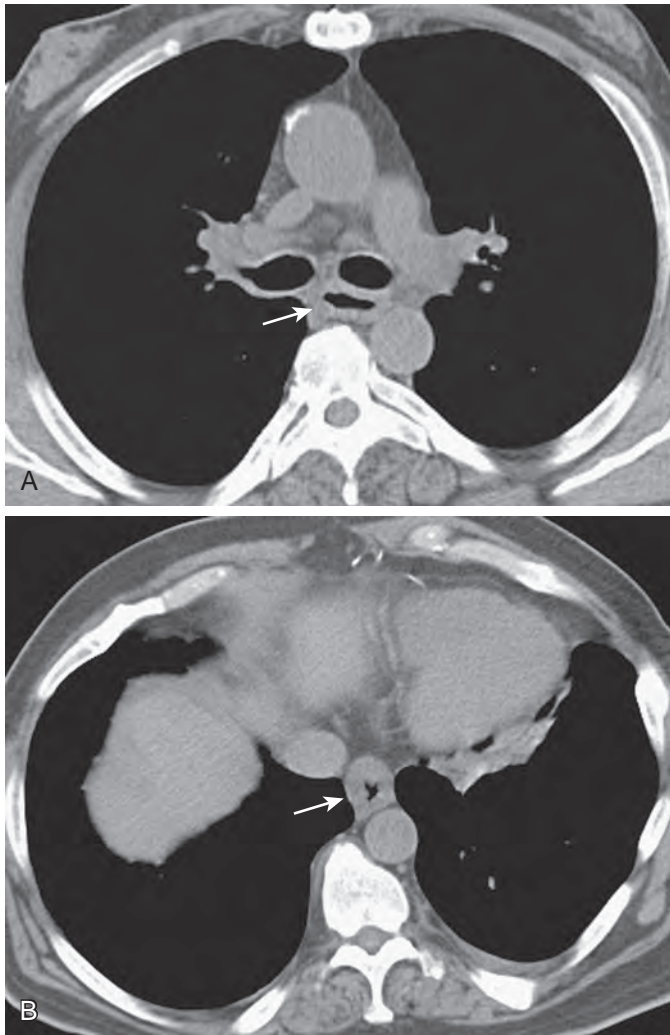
Diffuse esophageal spasm on CT. Axial contrast-enhanced CT images of the chest show moderate esophageal wall thickening (arrow) just below the carina (A) and even greater esophageal wall thickening (arrow) more distally (B). Barium esophagography revealed characteristic findings of diffuse esophageal spasm with multiple nonperistaltic contractions at fluoroscopy. Esophageal wall thickening is thought to result from progressive hypertrophy of the muscularis propria in these patients. (From Goldberg MF, Levine MS, Torigian DA: Diffuse esophageal spasm: CT findings in seven patients. *AJR* 191:758–763, 2008.)
